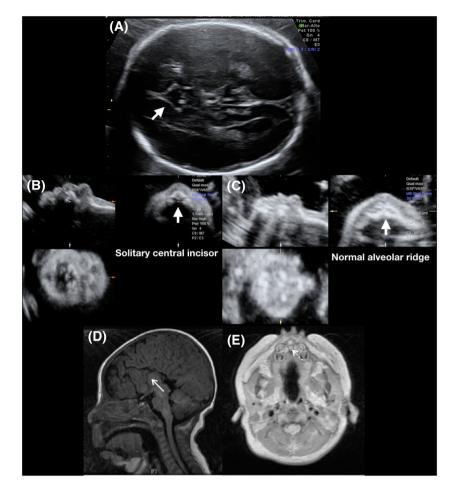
A, Fetal ultrasound examination at 27 + 4 wk of gestation of the case described in the main text. In axial planes, the cavum septum pellucidum is absent (arrow). B, Volumetric analyze archived in the database of the patient. The maxilla presents an abnormal alveolar ridge with a solitary central incisor. C, Volumetric analyses of a normal fetus with normal alveolar ridge. D, Postnatal MRI. In sagittal T1-weighted image, the corpus callosum is absent (arrow), abnormal profile with micrognathia. E, Magnet Resonance (RM) axial T1-weighted (threedimensional gradient dual echo) axial T1weighted images only a central incisor is present (dotted arrow). MRI, magnetic resonance imaging [Colour figure can be viewed at wileyonlinelibrary.com]
